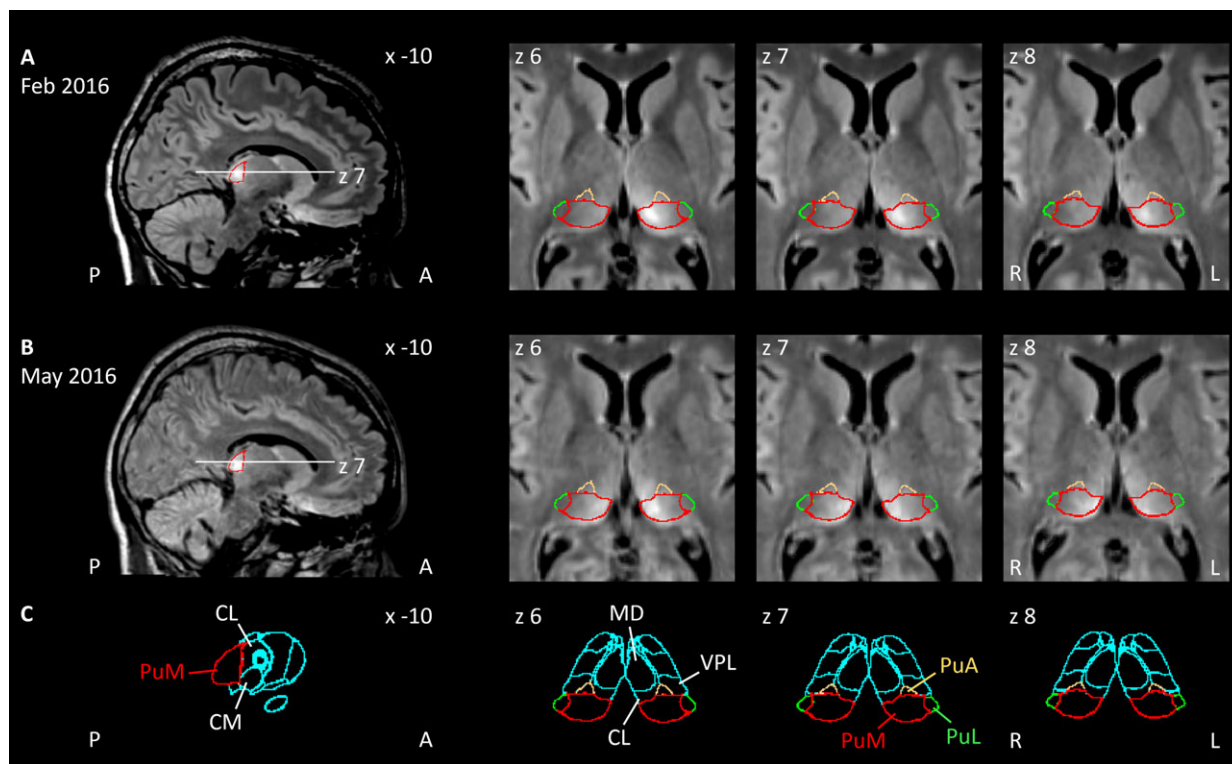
Magnified views of fluid-attenuated inversion recovery (FLAIR) MR images of the patient in MNI-space from (A) the first visit in February 2016, (B) the second visit in May 2016, and (C) co-registered to the digital version of the Morel atlas. The sagittal view on the left indicates the orientation and location of the axial cross-sections shown on the right. A: FLAIR images show hyperintensity in the medial pulvinar on both sides, stronger in the left pulvinar (radiological convention). Lesions spared the ventral pulvinar portions, anterior thalamus, brainstem, and surrounding cortices. B: On the second visit the bilateral involvement of the pulvinar became more obvious. Cross-sections show the lesioned thalamic regions based on the overlaid pulvinar regions defined by the Morel atlas. C: Corresponding sections of the Morel atlas with all regions are shown in the bottom row. The thalamic regions from the Morel atlas are outlined in light blue, except for medial pulvinar (PuM, red), lateral pulvinar (PuL, green), and anterior pulvinar (PuA, orange). Abbreviations: A, anterior; CL, central lateral nucleus; CM, centromedian nucleus; L, left; MD, mediodorsal nucleus; P, posterior; R, right; VPL, ventral posterior lateral nucleus. x, y, z (in mm) denote the level of the cross-sections in MNI-space.
